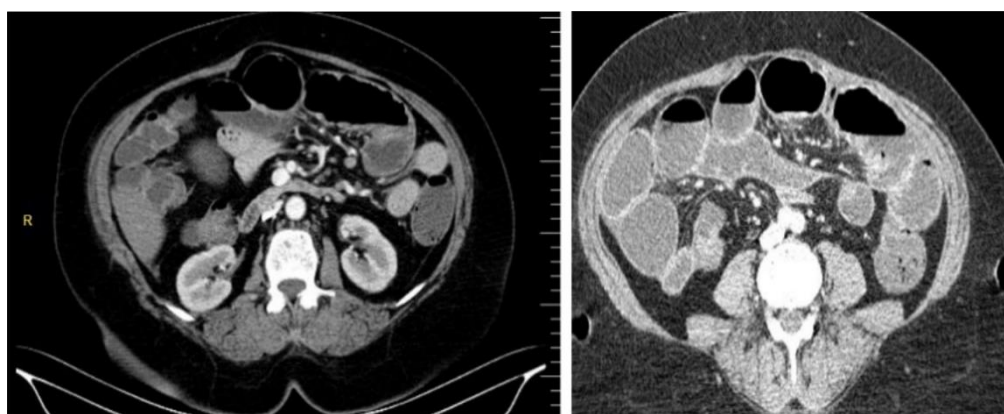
Computed tomography of the abdomen with intravenous contrast revealed distension of small bowel and fluid in the abdomen.
